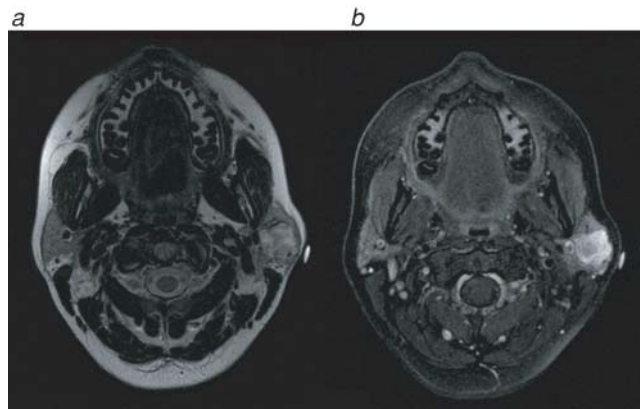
Axial (a) T₁ and (b) T₂ magnetic resonance images of a left superficial parotid pleomorphic adenoma demonstrating the classic irregular, bosselated appearance.
